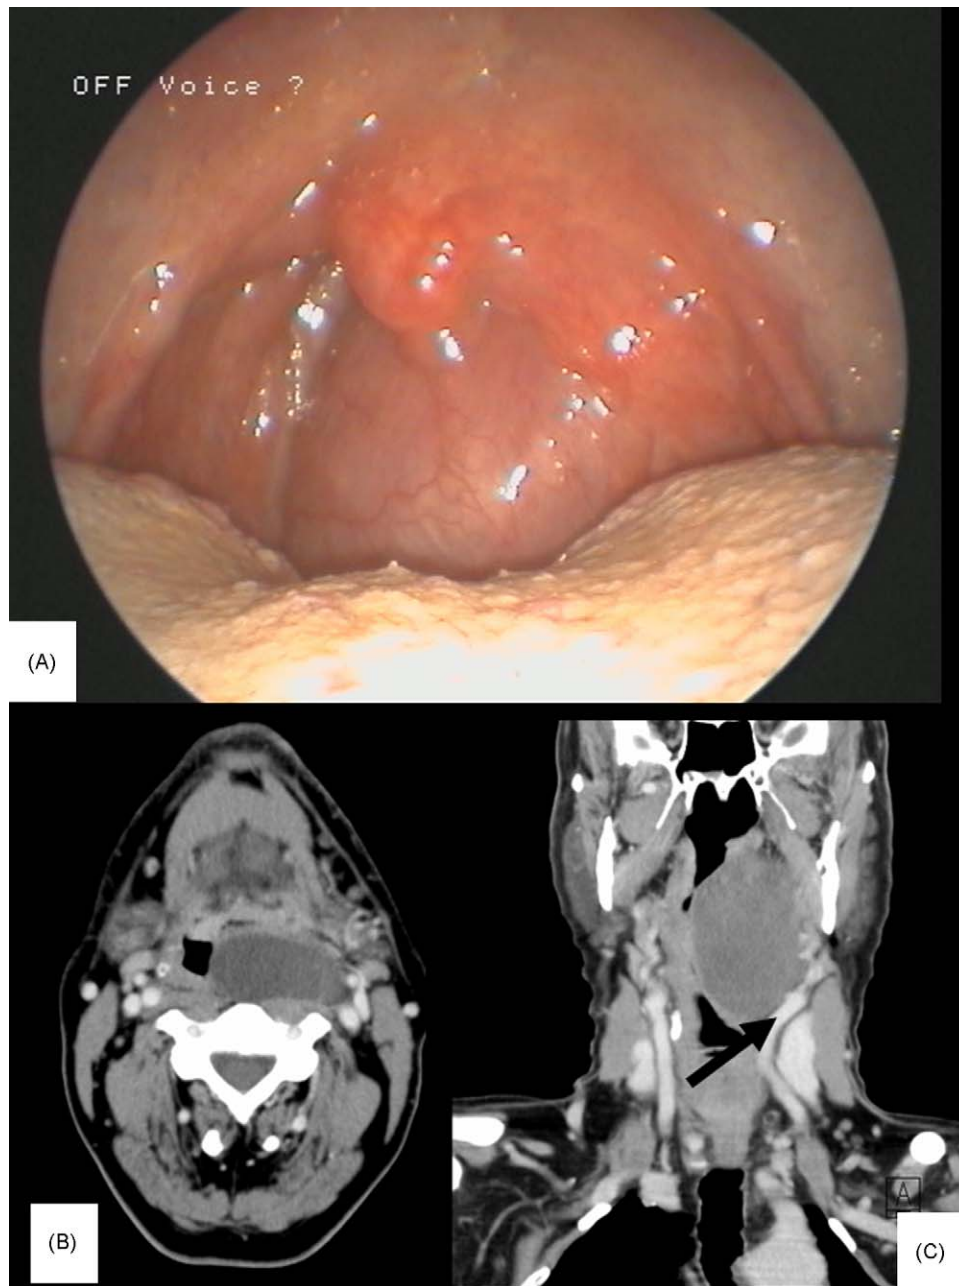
The para- and retropharyngeal cyst was observed directly when the patient opened his mouth (A). Axial (B) and coronal (C) head and neck CT-scans show the branchial cyst before the resection. The cyst filled the retropharyngeal and parapharyngeal spaces and displaced the left common -black arrow- and internal carotid arteries laterally.
